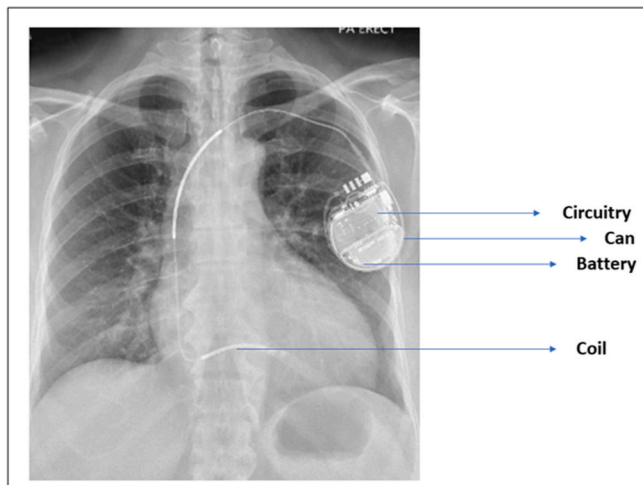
Radiographic parts of the cardiac implantable electronic device.
